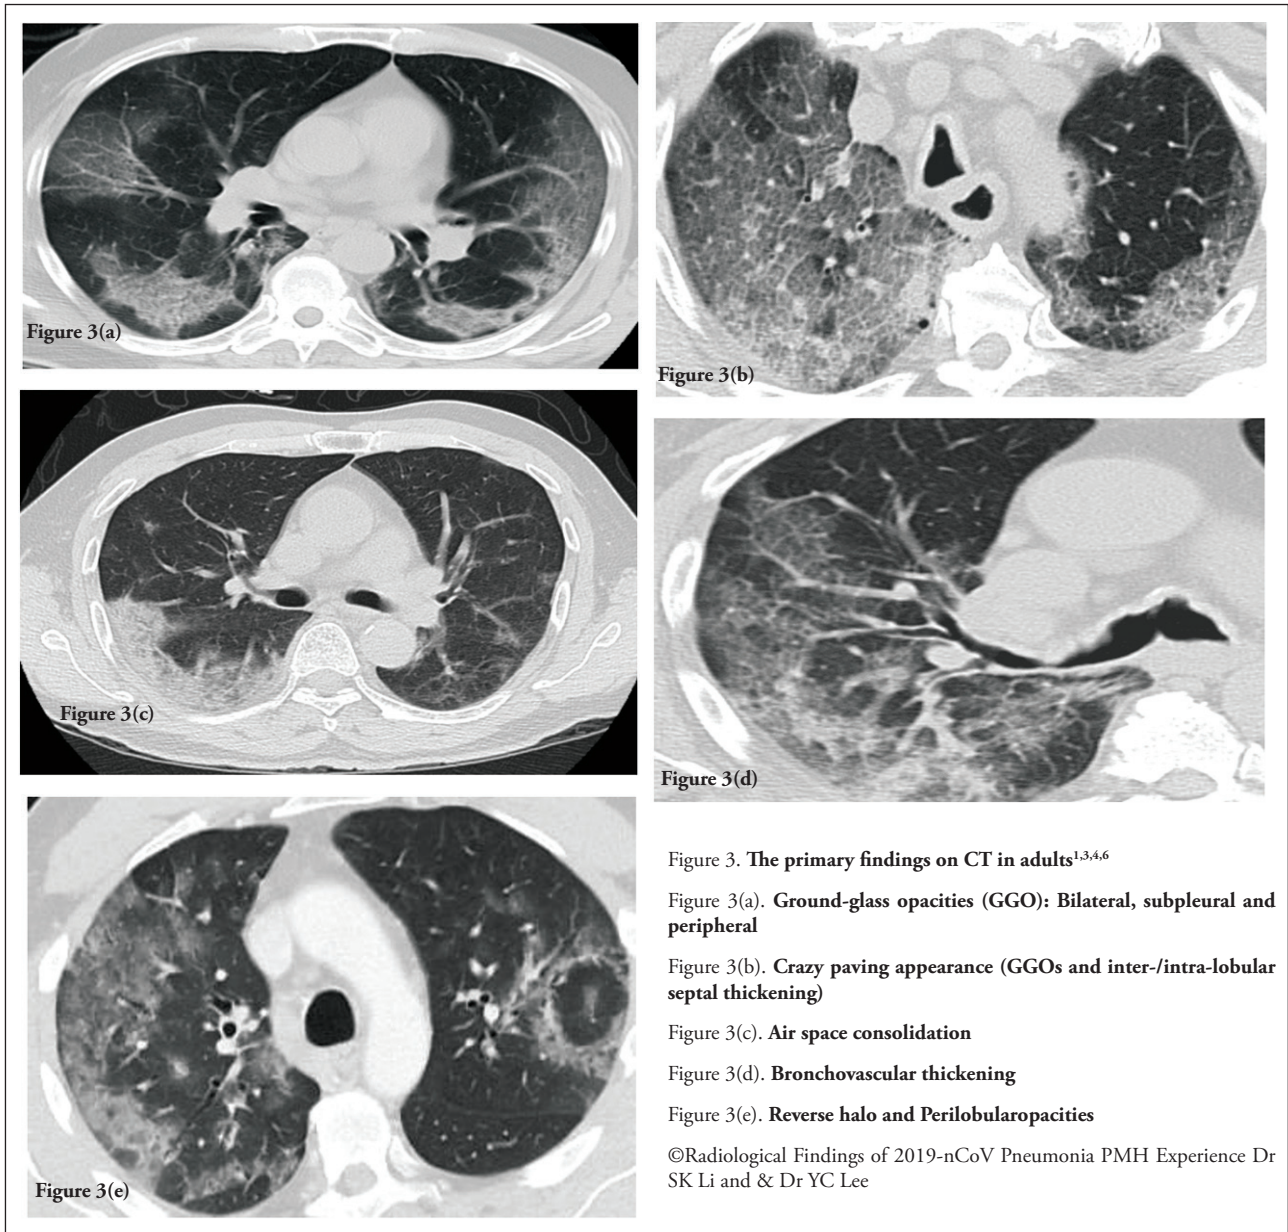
The primary findings on CT in adults^{1,3,4,6}
